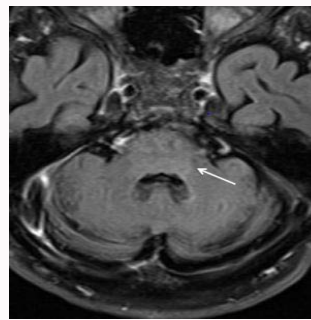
Partial regression of the hyper intense, non-enhancing tumor in the pons in FLAIR images (white arrow).
